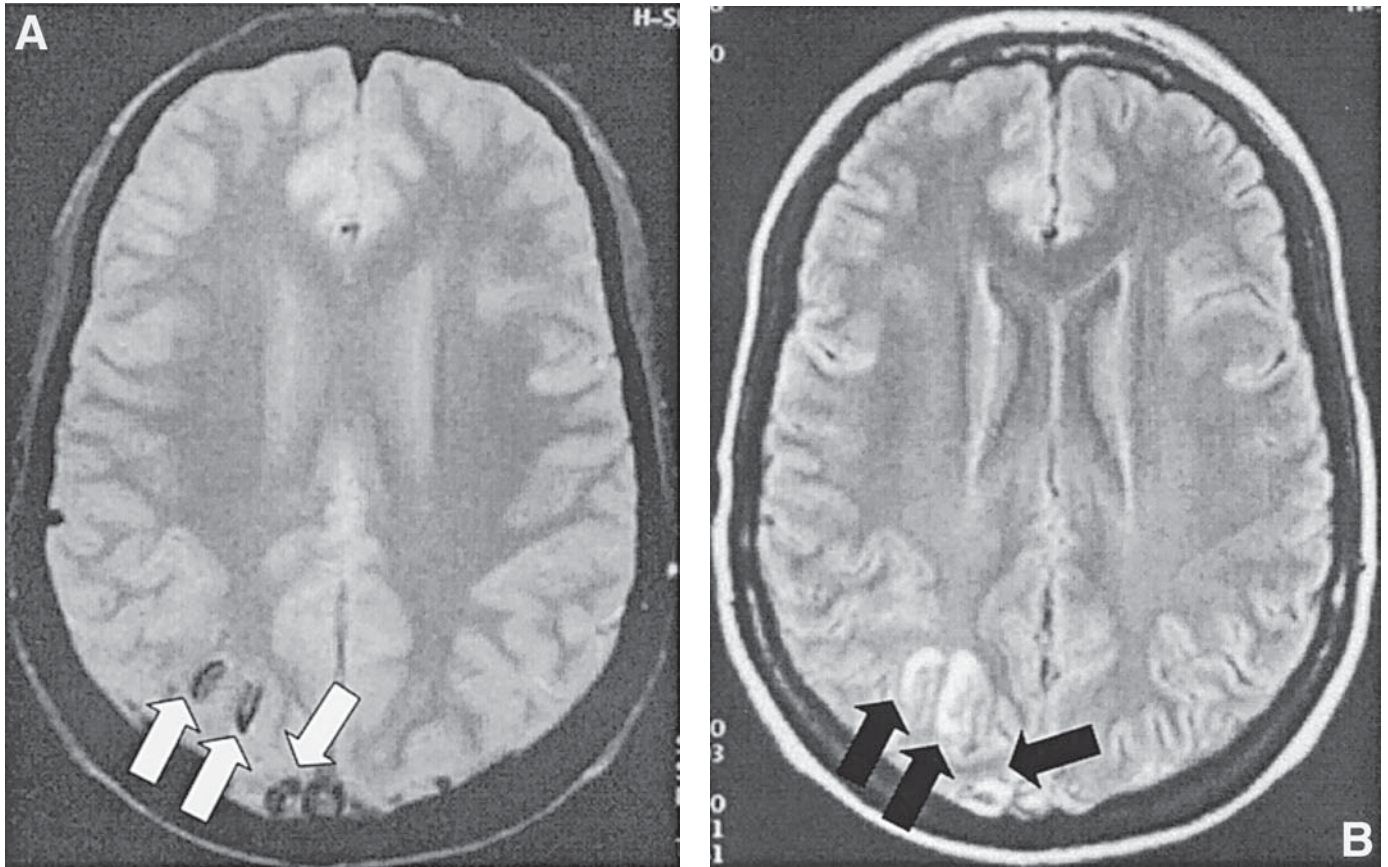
Cerebral venous thrombosis related to leukemia. A 31-yr-old woman with acute lymphoblastic leukemia presented with generalized tonic-clonic seizures. (A) Gradient refocused echo imaging and (B) FLAIR imaging show multiple small areas of hemorrhage (arrows). (C) (opposite page) Magnetic resonance venography reveals occlusion at the anterior and posterior portions of the sagittal sinus and near occlusion of the right transverse sinus at its origin (white arrows). The occluded sinuses were reopened with catheter-administered tissue plasminogen activator and rheolytic thrombectomy with the Angiojet device.
